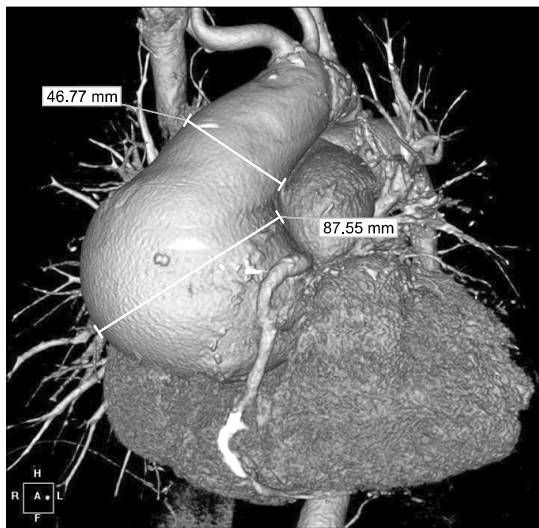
The huge saccular aneurysm (9 cm) of aortic root and proximal ascending aorta in computed tomography.
